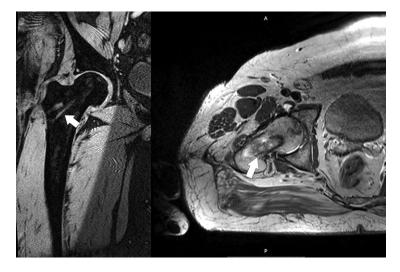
MRI of the left hip joint 12 months after the closed combined autografting of the femoral head; no pathologic changes in the femoral head, moderate trabecular oedema in the area of the muscle autograft is observed (indicated by arrows)
